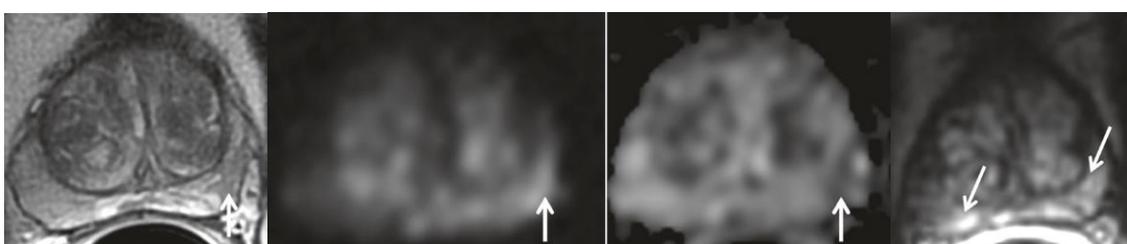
PI-RADS 3 category in PZ. First, axial T2WI. Second, b1400 DWI. Third, ADC map. Fourth, DCE at 10 seconds. Shows a mildly focal high signal area on DWI and mildly hypointense on ADC (arrows) in the left PZ, corresponding to an intermediate signal intensity on T2WI. DCE shows early diffuse uptake of the PZ bilaterally (arrows), indicating negative contrast assessment. Obtained from (12).
